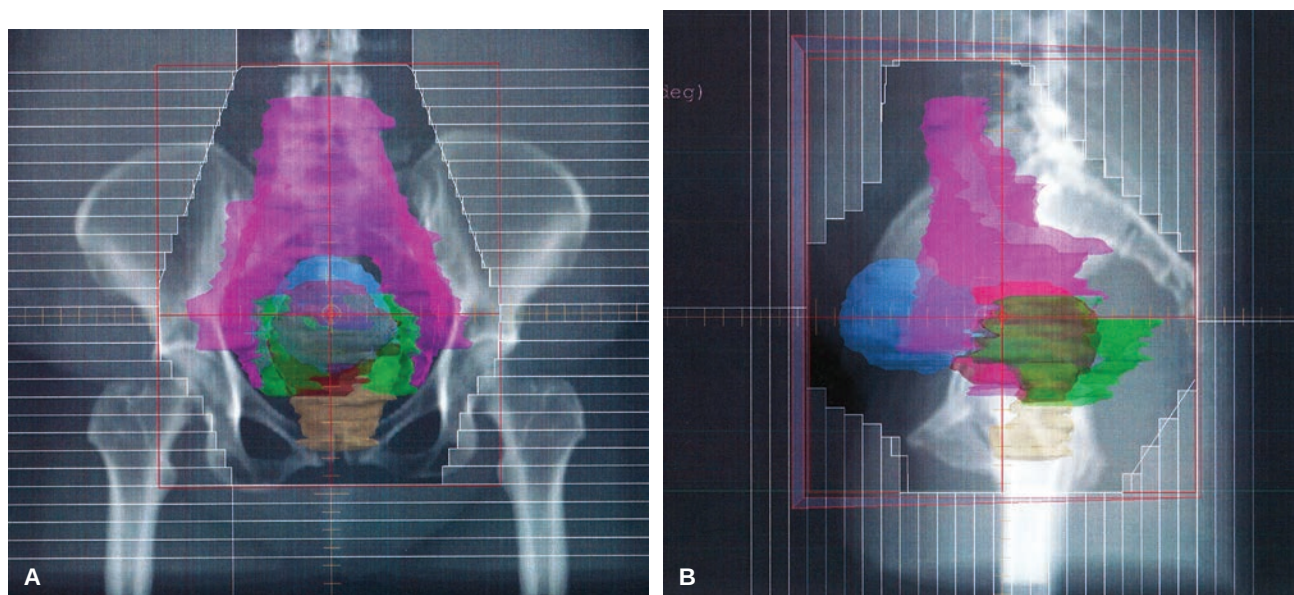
Digitally reconstructed AP A: and lateral B: radiographs with associated contoured targets including the pelvic lymph nodes and uterus/cervix/parametria and vagina. Note the multileaf collimator leaves defining the field shape in accordance with coverage of the targets of interest.
